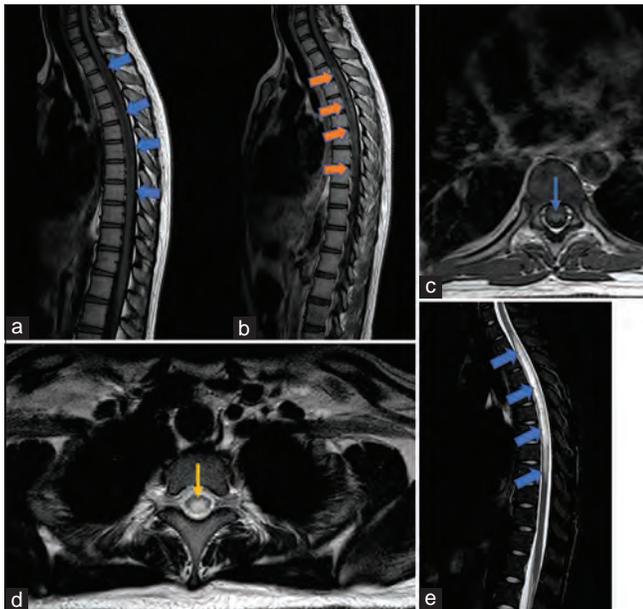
An expansile, long-segment diffuse intramedullary mass involving the thoracic spinal cord extending inferiorly (from T2-T10). The mass appears isointense on T1 weighted (a) and hyperintense on T2-weighted images (d and e) with peripheral contrast enhancement (b and c). Features reported to be suggestive of a spinal astrocytoma
